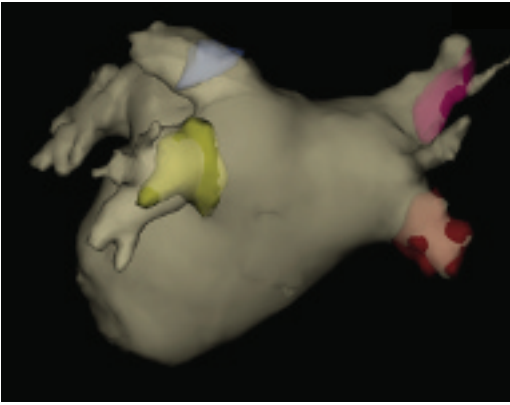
Complete integration of a preacquired 3D CT image (NavX fusion algorithm) of the left atrium. The surface of the four pulmonary veins has been reconstructed using a Lasso catheter for automatic acquisition of anatomical points. Each pulmonary vein was reconstructed in a separate anatomy (blue: left upper PV, yellow: left lower PV, red: right upper PV, brown: right lower PV). These reconstructed anatomies served as landmark surfaces for alignment and integrating of the CT image. The anatomy of the body of the left atrium was not reconstructed.
